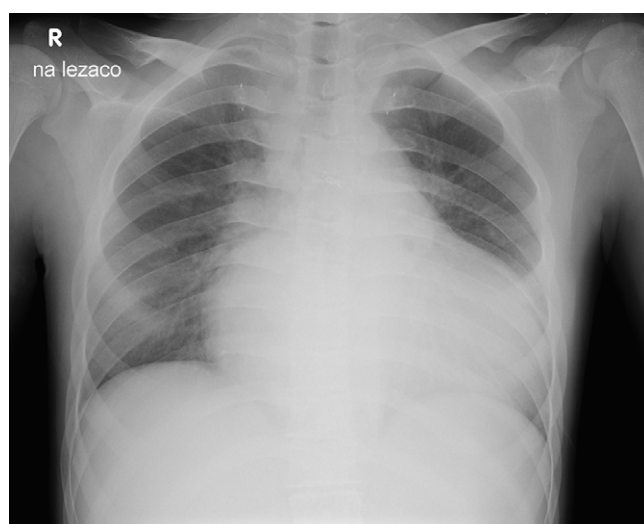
Chest X-ray exam (before levosimendan administration) shows significantly enlarged cardiac silhouette with pulmonary venous congestion.
